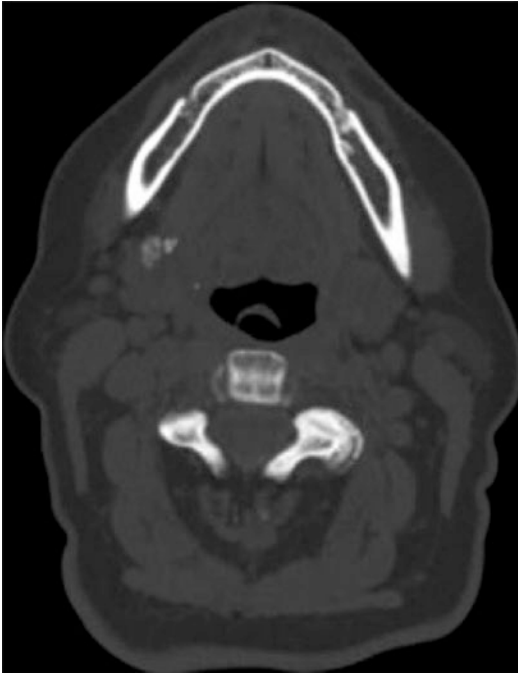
CT scan from Fig. 20.3, on bone window, demonstrating variable density within the larger calcification
